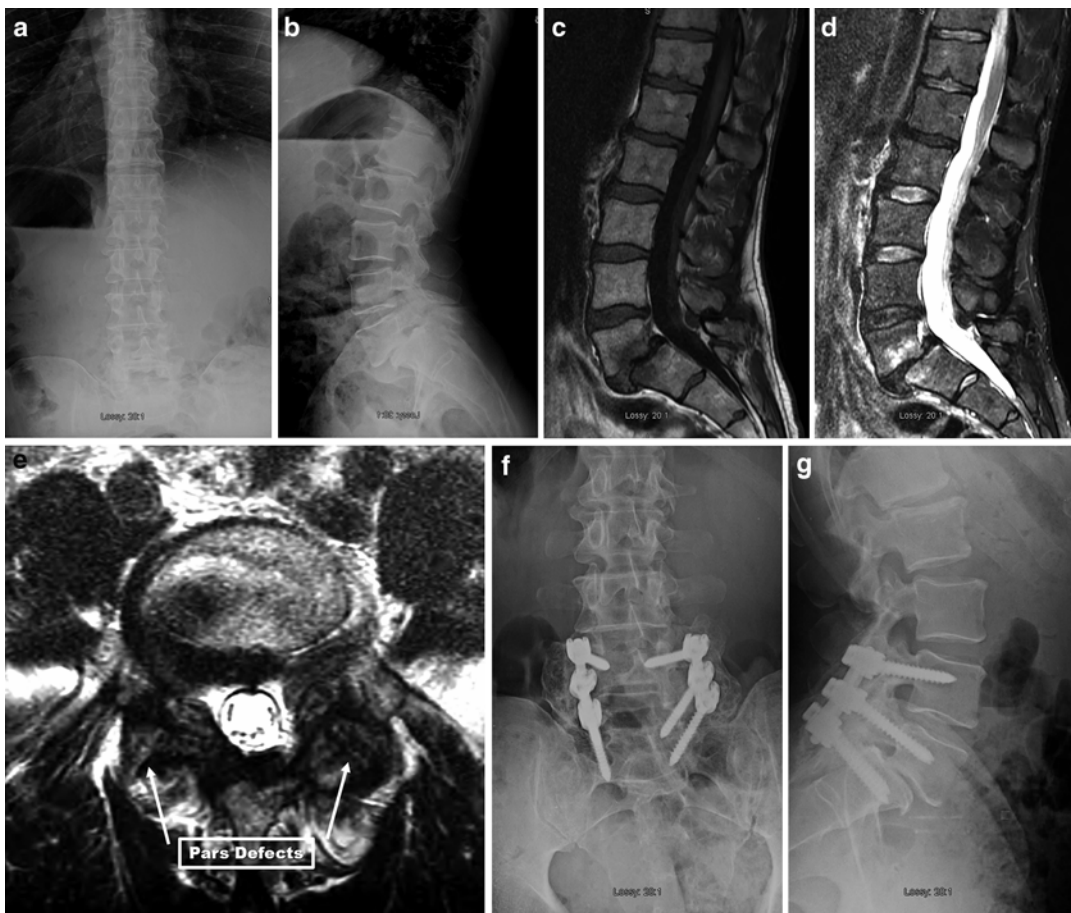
Fifty-two-year-old male presented with many years of mechanical low back pain, now has persistent bilateral L5 radicular symptoms refractory to NSAIDs, physical therapy and epidural blocks. He was treated with an L4–S1 decompression, posterolateral fusion using iliac crest and local bone graft. (a, b) Anterior–posterior and lateral radiographs showing a *grade II isthmic spon-*
